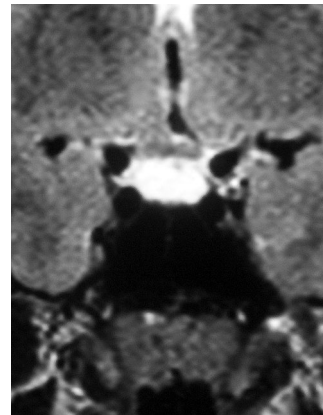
Coronal T2-weighted image show no evidence of anterior pituitary tissue.
